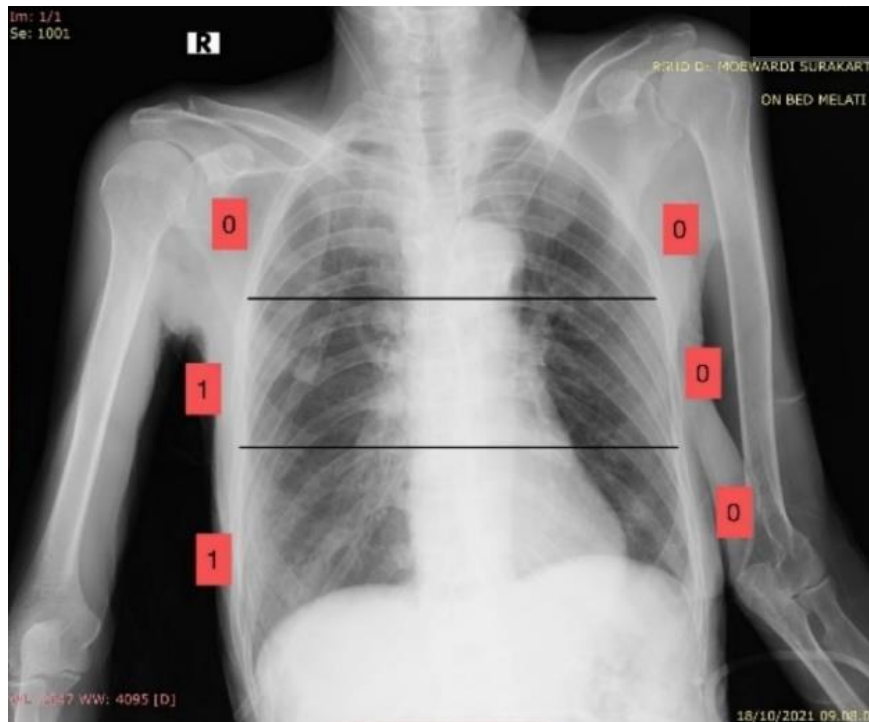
Chest x-ray of patient live with mild category of Brixia Score
